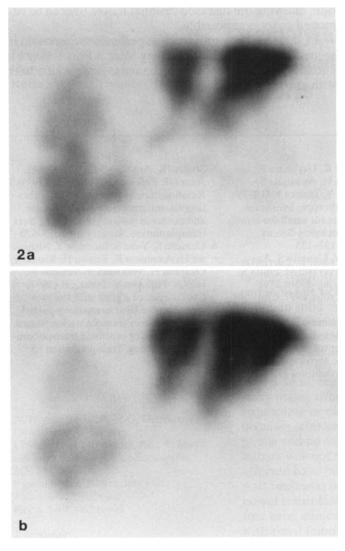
b [^{99m}TC]-galactosyl serum albumin scintigraphy. a Two weeks after APOLT. b One month after APOLT
